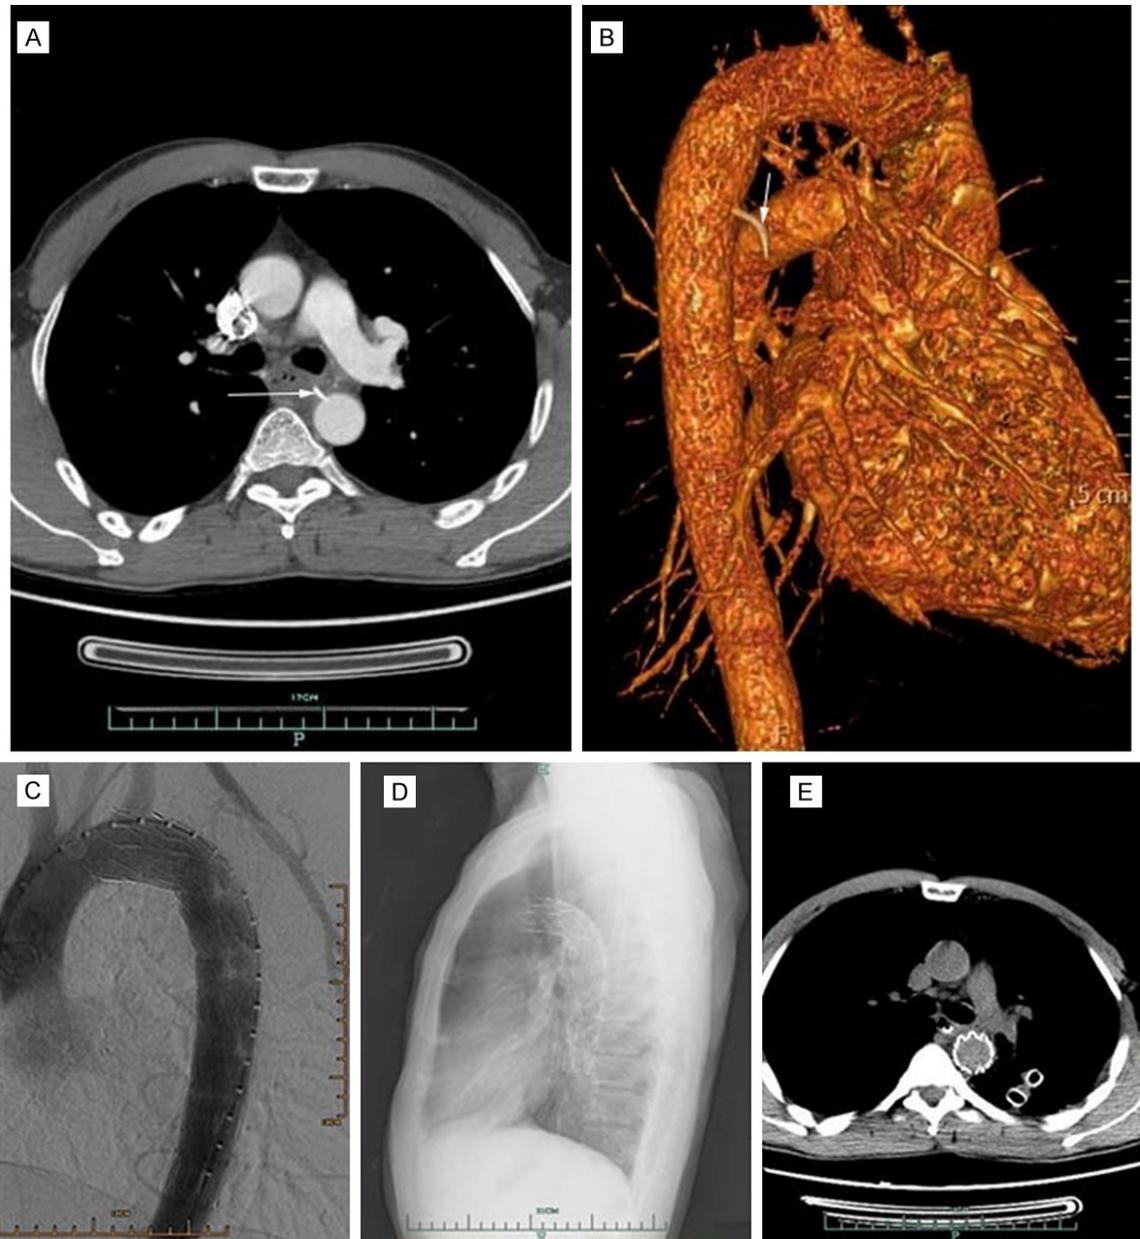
(Case 3), CTA (A) and MPR (B) preoperatively showed the sharp foreign body (arrow) piercing the aorta through the esophagus. Intraoperative completion angiogram showing complete coverage of traumatic aorta by the stent graft (C). Postoperative X-ray (D) and CT (E) showed satisfactory results and no signs of inflammation half a month later.
